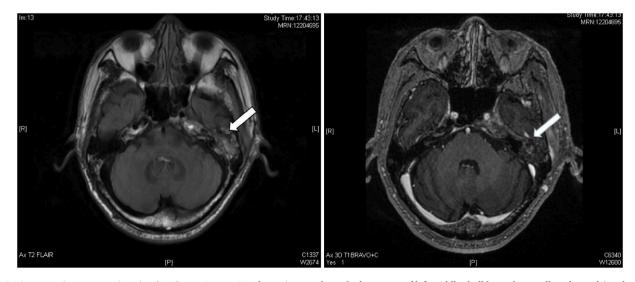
Brain magnetic resonance imaging (MRI) scan Images. Head scan images showed a large area of left middle skull base abnormally enhanced (marked by the white arrow) (day +2).
